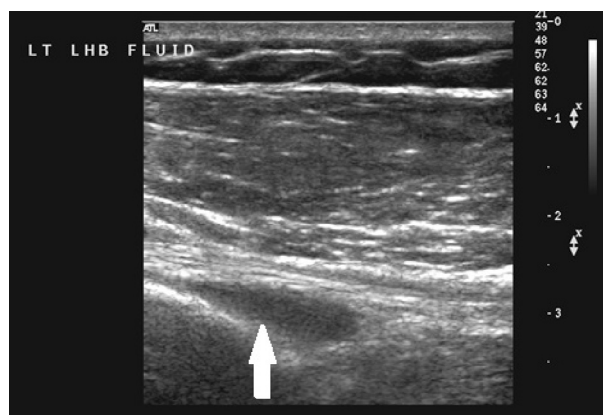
Ultrasound image visualizing long head of biceps (LHB) in longitudinal plane.
